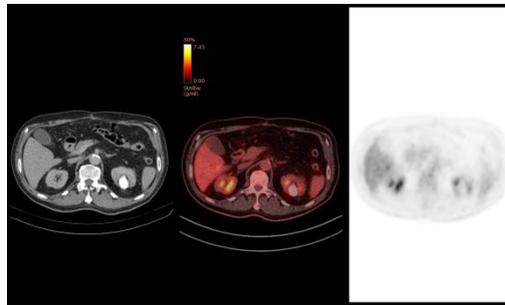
75 years old patient treated of rectal cancer, stage IIIA. Patient was referred to PET/CT due to suspected peritoneal lesions. PET/CT did not detect peritoneal metastasis but FDG avid liver lesion in segment 6 was identified.
